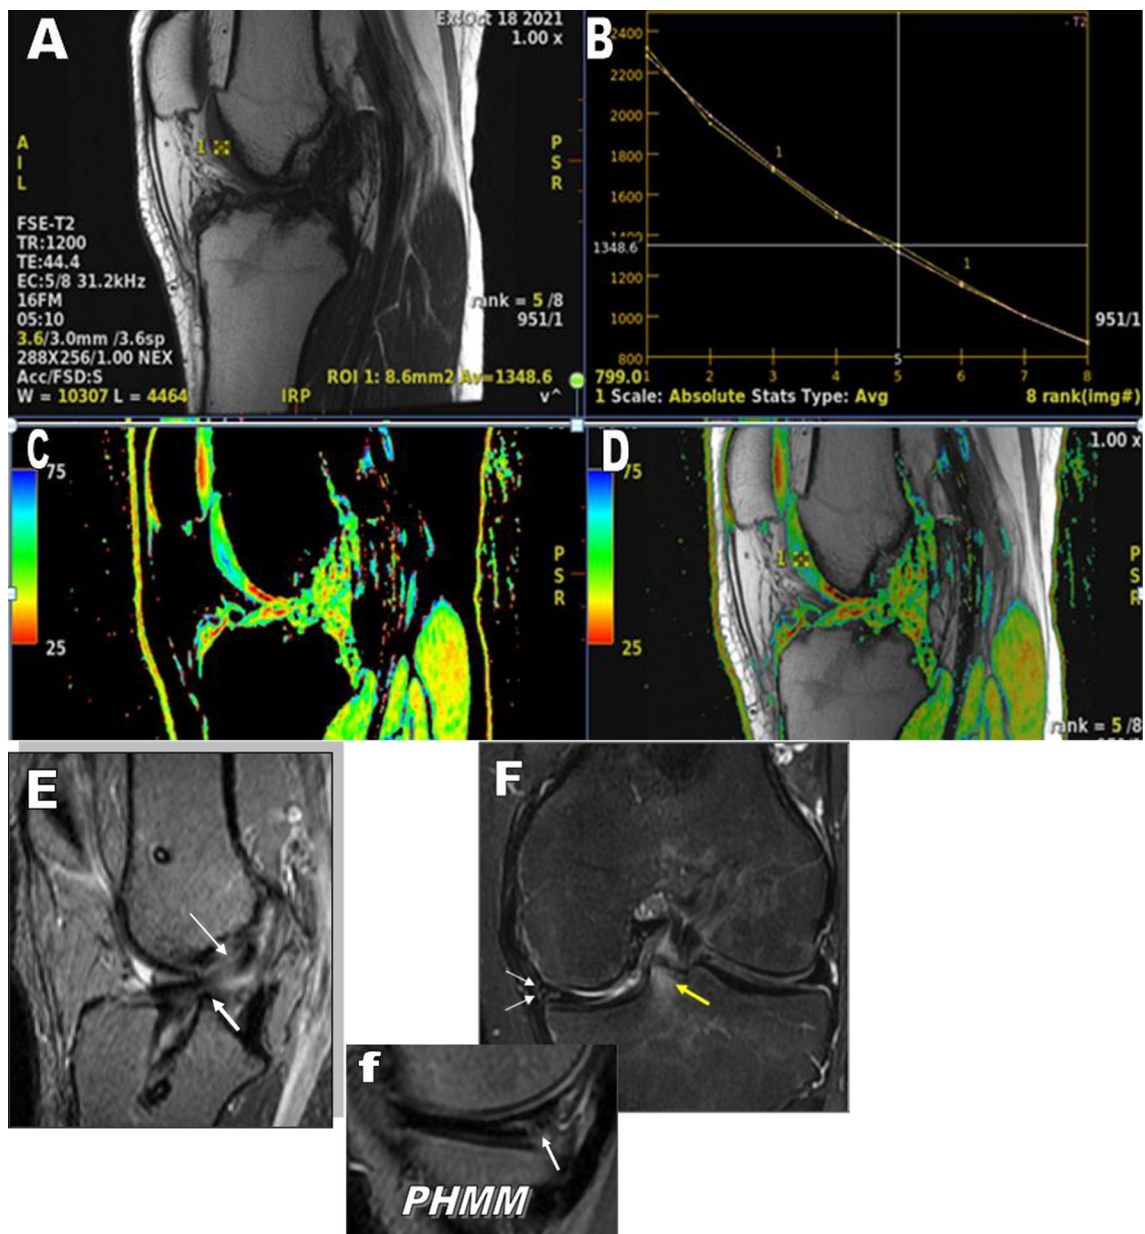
A 24-year-old male patient underwent ACL reconstruction 3 years ago, the patient complained of knee pain and swelling. In assessment of the MRI knee, the conventional images shows and mild knee joint effusion. Intact ACL graft showing normal position and taut signal, no evidence of tearing or related complications. Sagittal T2 image (A) along the medial femoral condyle level shows intact articular cartilage upon the posterior segment with subtle intrasubstance high signals (Arrow). On the post processing T2 mapping image; (C, D) The colour image along the articular cartilage of the medial femoral condyle posterior segment revealed internal areas of blue colour within the deep layer (white arrows) with increased T2 value (as demonstrated within the curve image (B)) that corresponds to articular cartilage degeneration. According to the international cartilage Repair Society (ICRS) grading system, this corresponds to grade I cartilage degeneration. Sagittal T2 image (A) at lateral femoro-tibial articulation level shows intact articular cartilage overlying the posterior segment of the lateral tibial condyle with intrasubstance high signal. On the post processing colour coded T2 mapping image: (C, D) The colour images along the articular cartilage of the lateral tibial condyle posterior segment revealed internal focal area of green colour (arrows) with increased T2 value (as demonstrated within the curve image (B)) that corresponds to articular cartilage degeneration. According to the international cartilage Repair Society (ICRS) grading system, this corresponds to grade I cartilage degeneration
